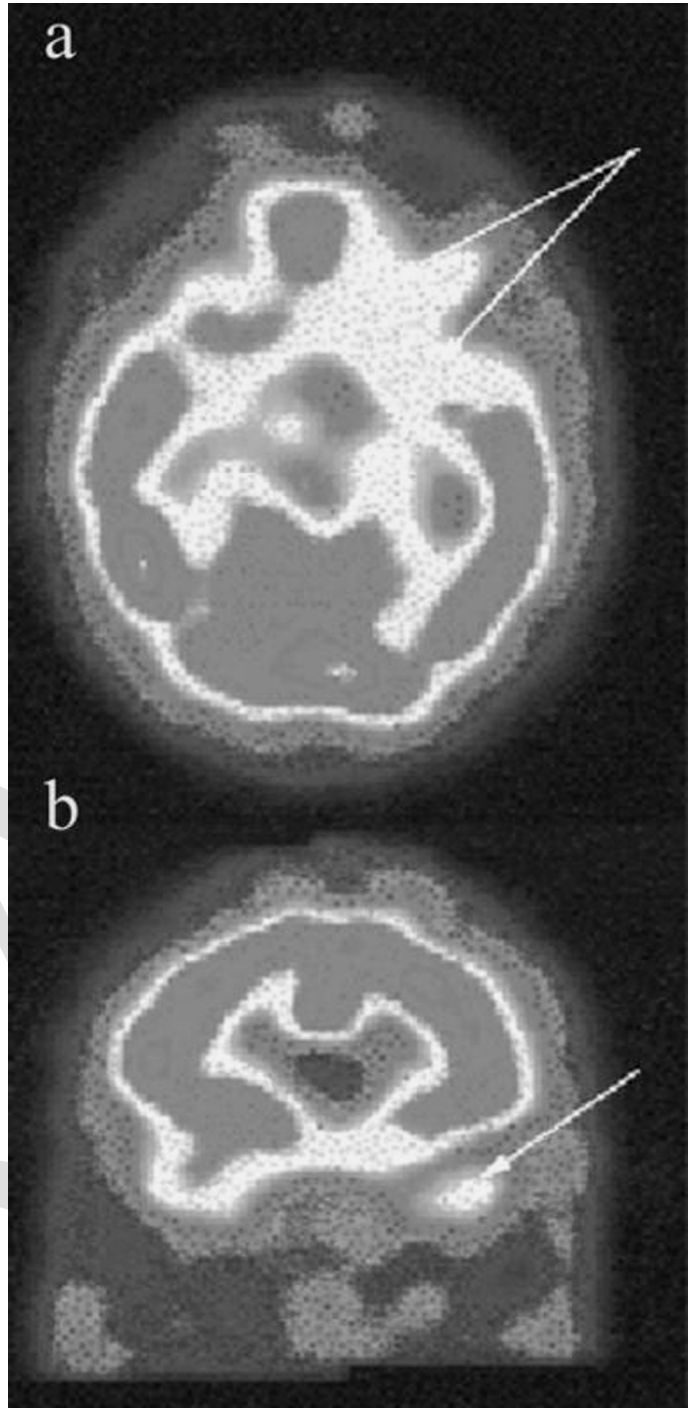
SPECT images of TG's brain. Horizontal (a) and coronal (b) sections show respectively a blood flow reduction in the left orbitofrontal cortex and in the anterior part of the left temporal lobe involving the periamygdalar region.
